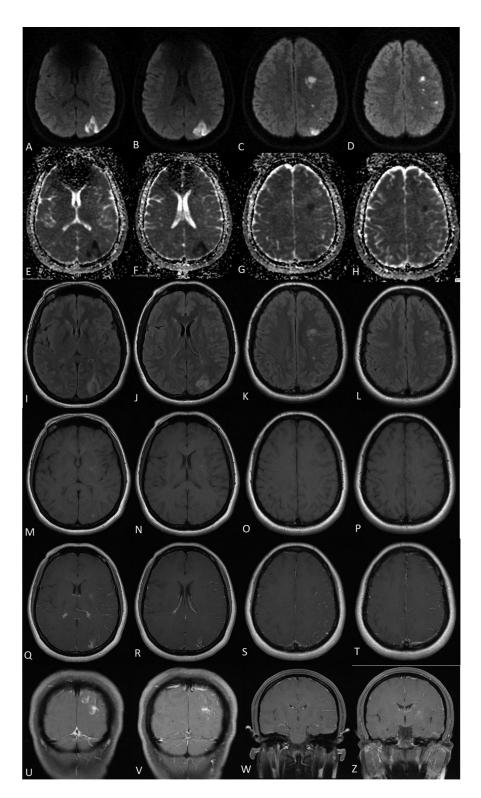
Axial DWI (diffusion weighted imaging) (A-D), axial ADC (apparent diffusion coefficient) (E-H), axial T2 FLAIR (I-L), axial T1 pre- (M-P) and post-contrast (Q-T) as well as coronal T1 post-contrast (U-Z) brain MRI from day of admission showing numerous foci of ischemic infarcts involving left cerebral hemisphere, a few of them are in subacute stage and show enhancement and hemorrhagic transformation. There is also a left basal ganglia focal enhancing lesion with T1 hyperintensity and without diffusion restriction (indeterminate in nature).
